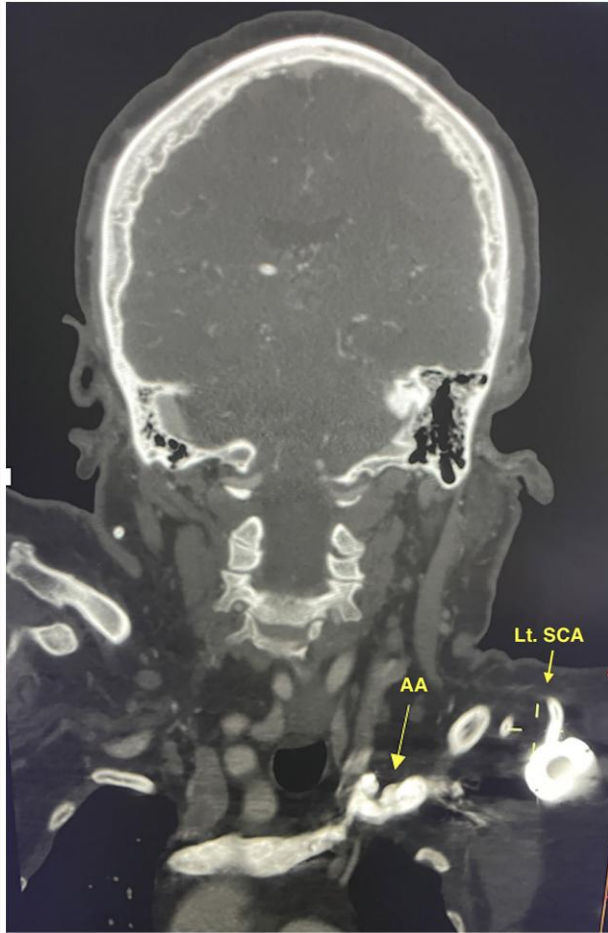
Head and neck computed tomography angiography shows the chemoport entering through the left subclavian artery with the distal tip projecting towards the aortic arch. LSCA, left subclavian artery; AA, aortic arch.
